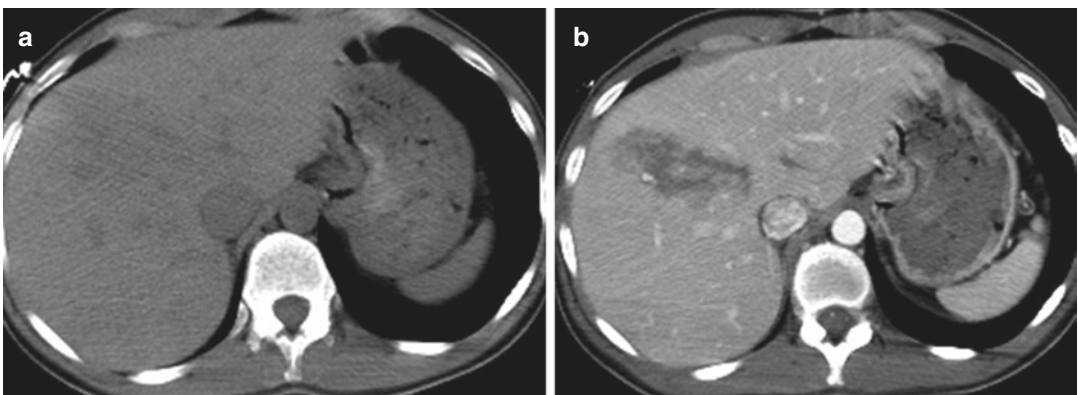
Contrast-enhanced CT (a–d) confirms the lesions demonstrated by CEUS
